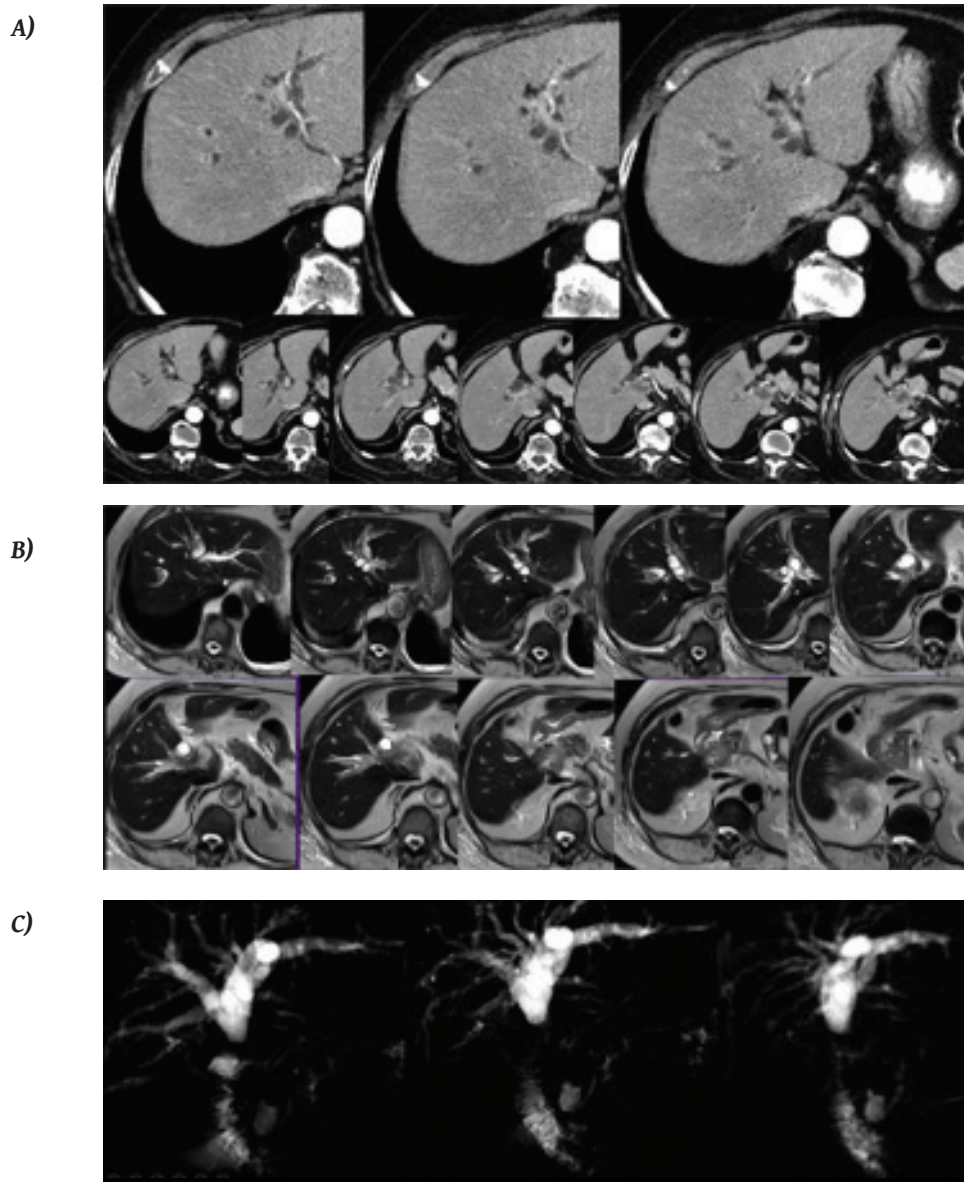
Intrahepatic peribiliary cysts and Cholangiocarcinoma. a) axial CT scans and b) MR T2WI axial scans, which reveal peribiliary cysts and a lesion in the caudate lobe of the liver, proved to be a Cholangiocarcinoma. c) MRCP which clearly depicts the level of the obstruction of the common hepatic duct and the peribiliary intrahepatic cysts.
